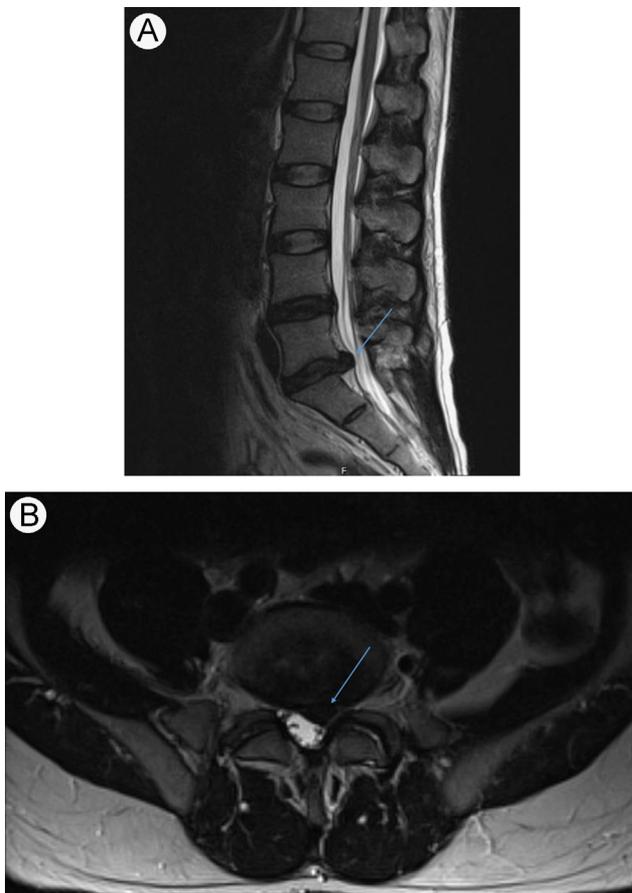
Classic left posterolateral herniation at L5-S1 demonstrated with (A) sagittal and (B) axial T2-weighted MRI.
